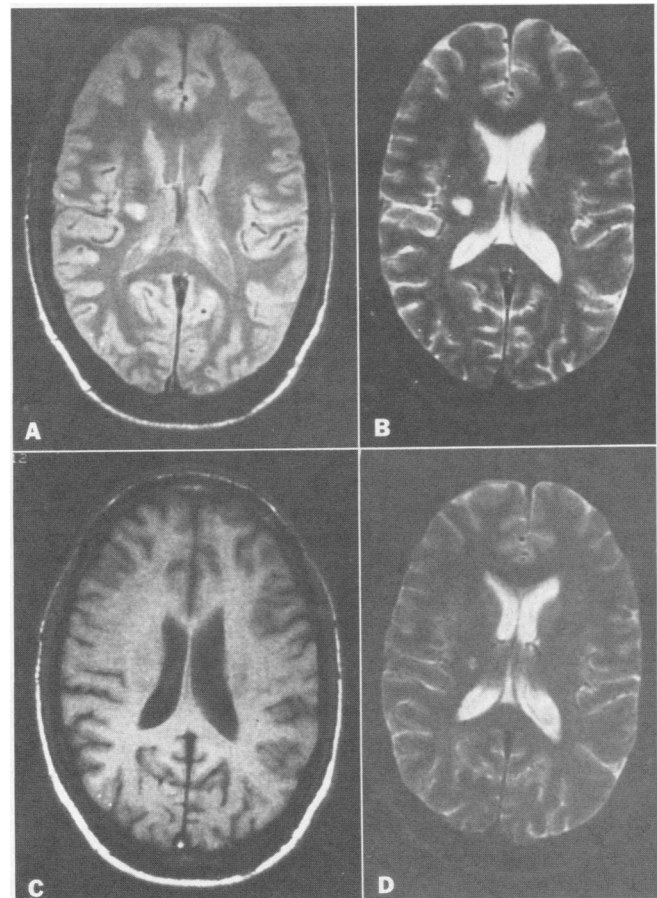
Brain magnetic resonance imaging: Spin-echo sequences include a proton-weighted first-echo (TR = 2,000, TE = 20 milliseconds) image (A) that shows a right internal capsule abnormality with greatly increased signal intensity on a T2-weighted second-echo (TR = 2,000, TE = 80 milliseconds) image (B) but no signal abnormality on a T1-weighted (TR = 800, TE = 20 milliseconds) image (C). Two months later, the lesion size and signal intensity are decreased, as shown in a T2-weighted image (D).
